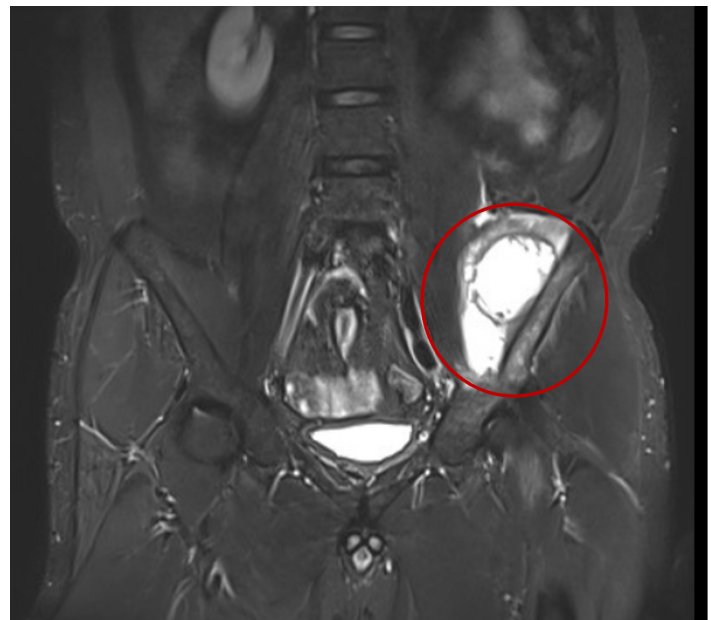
Representative coronal section of MRI demonstrating a cystic lesion underneath the iliac muscle.
